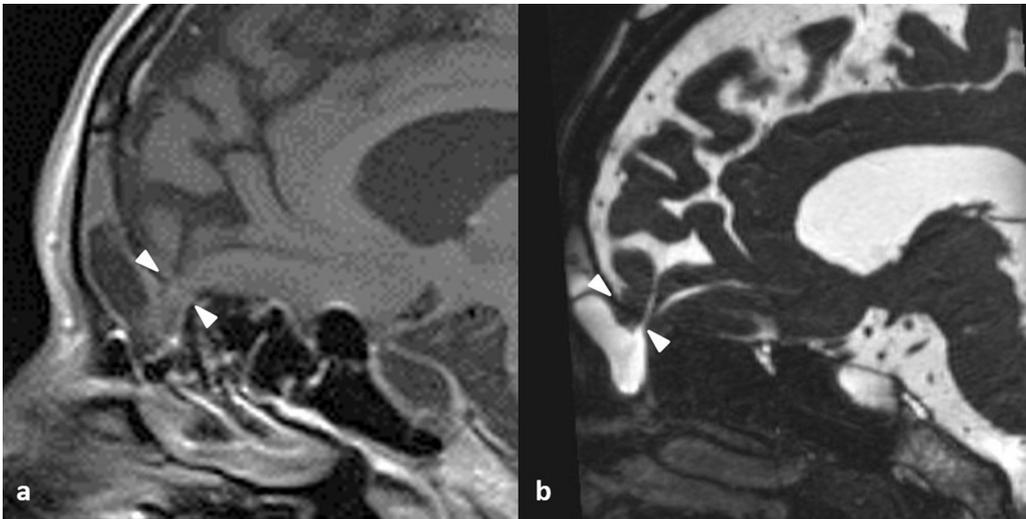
Forty-two-year-old woman with watery nasal discharge from left side: a–b: sagittal T1-weighted and MR cisternography images show herniation of frontal parenchyma (i.e. meningoencephalocele through the defect in posterior wall of frontal sinus) (arrowheads).
